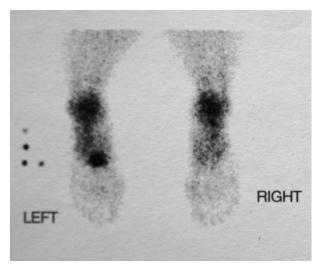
Bone scan of base left 2nd metatarsal stress fracture in ballet dancer. Radiograph was negative.
